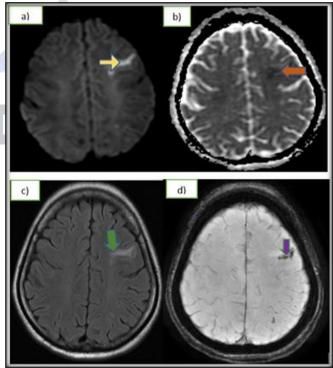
(a-d)- Acute Infarct with early hemorrhagic transformation in cortical and subcortical region of left frontal lobe. There is diffusion restriction (yellow arrow) with corresponding decrease in the ADC values (red arrow) noted in Fig a) and B). FLAIR image(c), showing hyperintense signal (Green arrow) and foci of blooming (purple arrow) on SWAN(d) in the involved region
